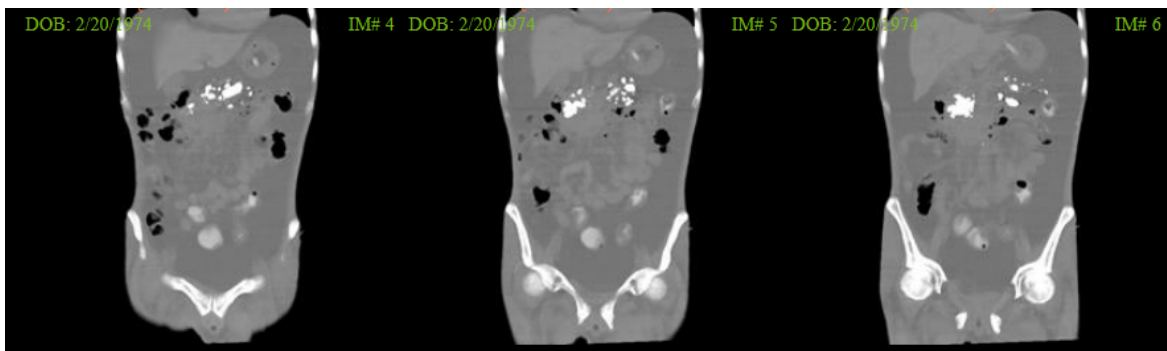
CT Scan Shows Multiple Calcification of pancreas
